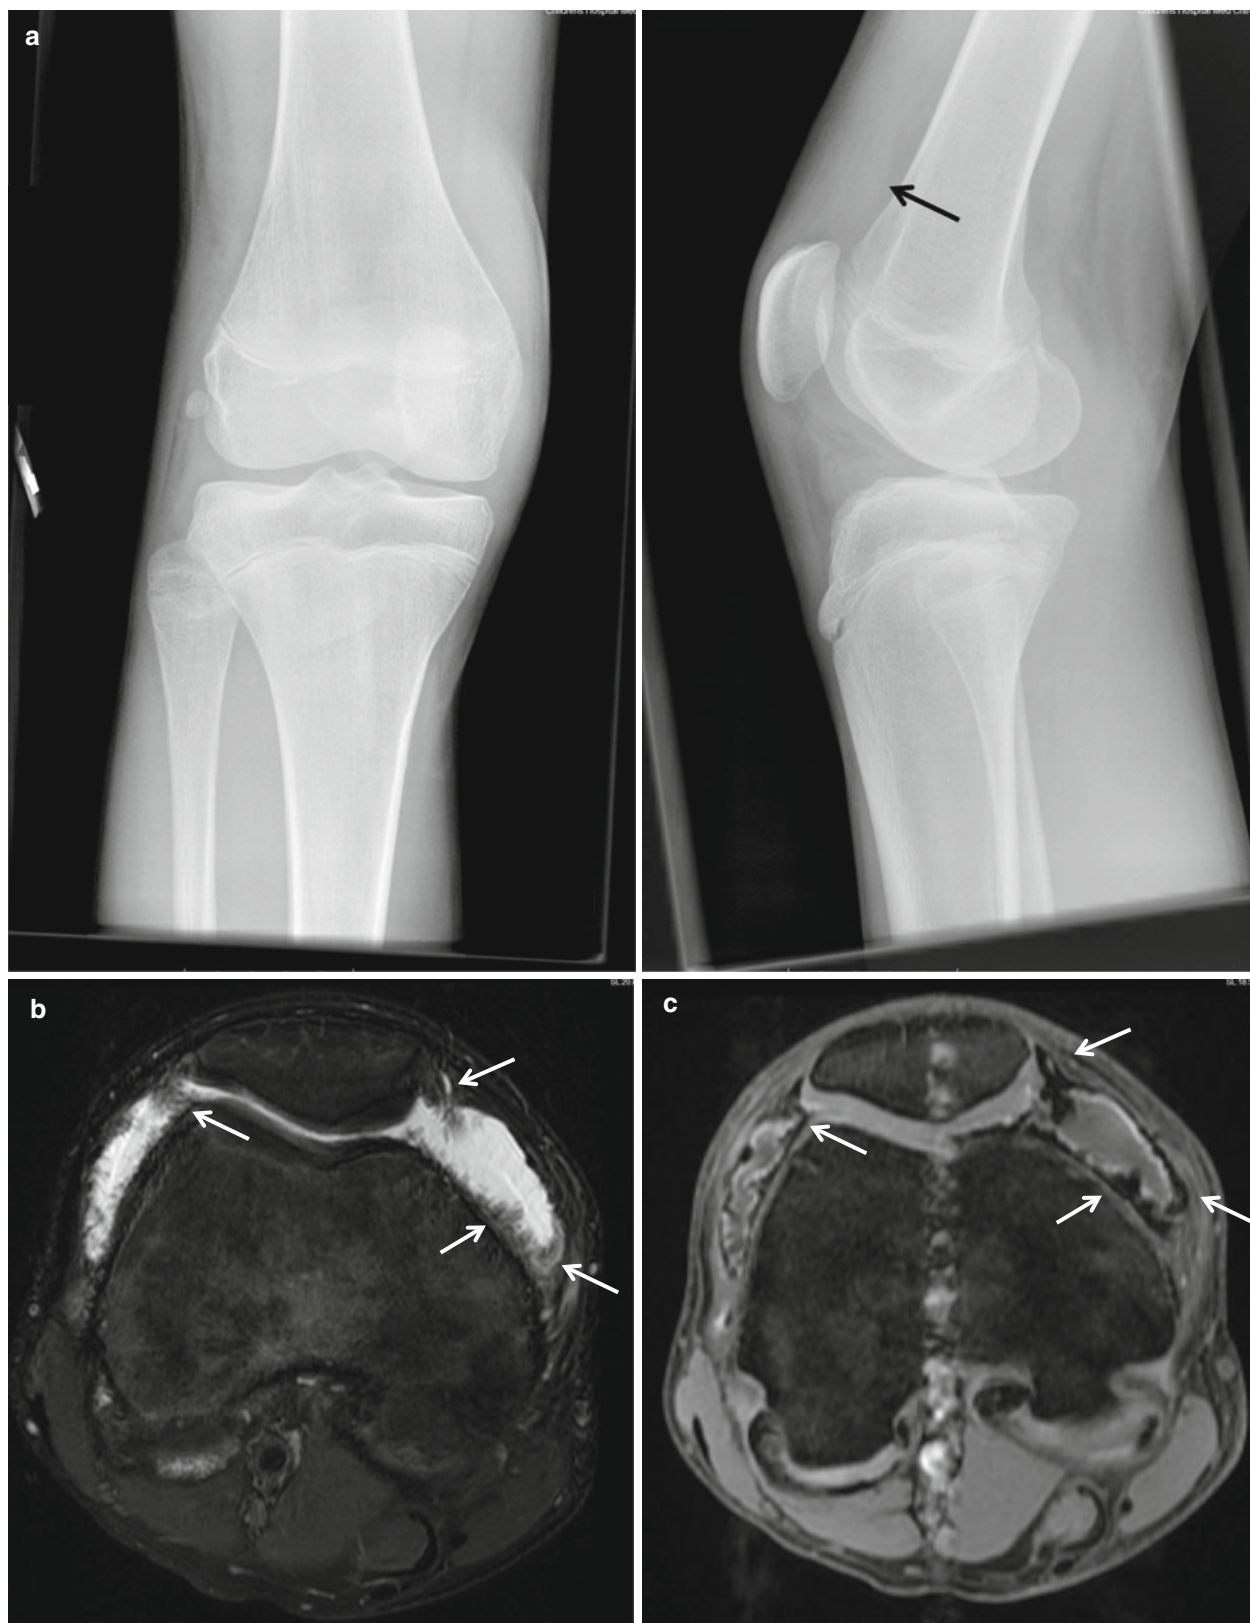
A 13-year-old boy with diffuse pigmented villonodular synovitis (PVNS). (a) Plain radiograph demonstrates joint effusion (arrow). There is no bone erosion or calcification. (b, c) Axial T2-WI with fat suppression (b) and gradient echo sequence (c) demonstrate
